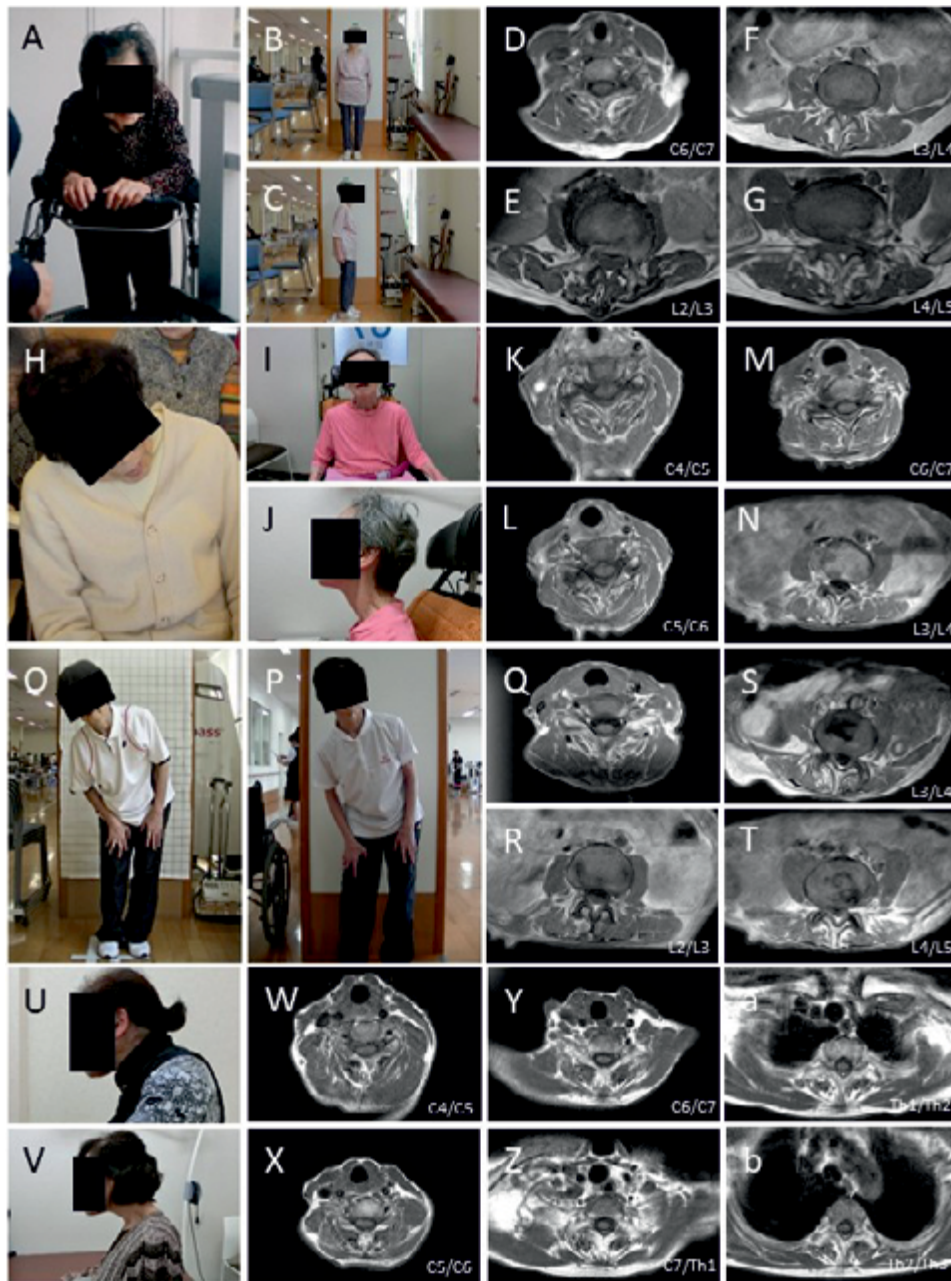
Description of patients before and after initiation of istradefylline and MRI observations.
